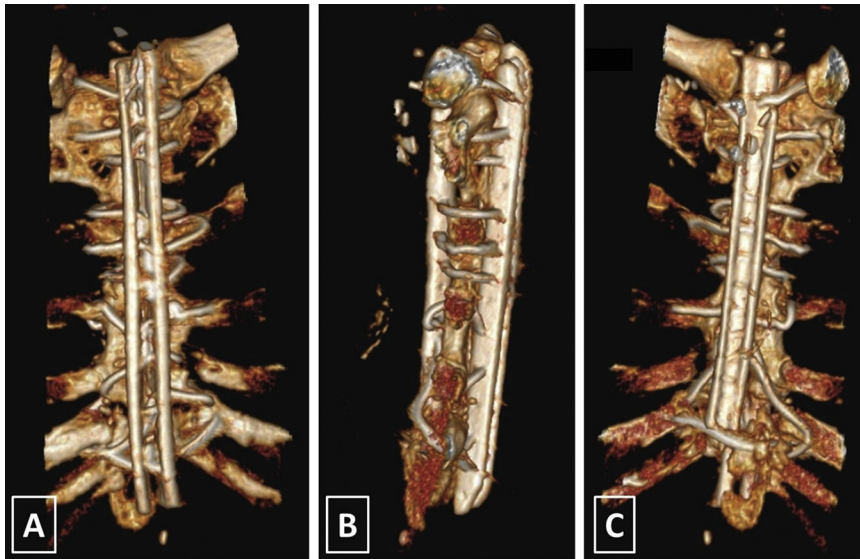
Three-dimensional computed tomography after the sternal reconstruction with (A) anterior, (B) lateral, and (C) posterior projections.
